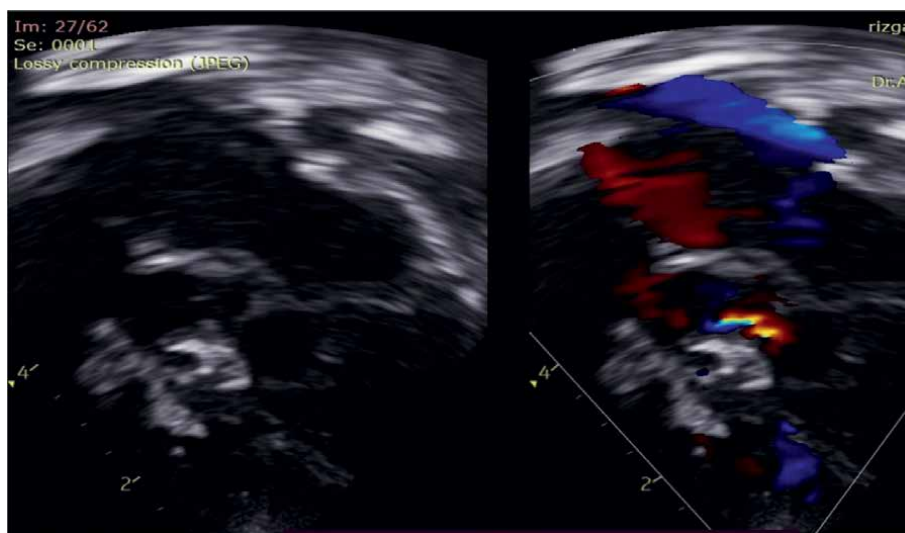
Subcostal echocardiography shows the device in place with mild aortic incompetence.
